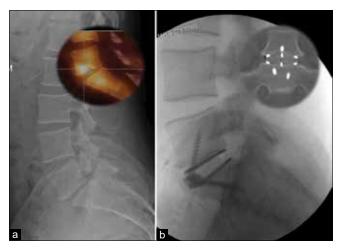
Stand alone Anterior Lumbar Interbody Fusion for Isthmic Spondylolisthesis. (a) Standing X-ray. Degenerative Disc Disease with low-grade spondylolisthesis and pars defect. *Insert*. Discovertebral uptake on bone scan. (b) 6-month postoperative X-ray and (*Insert*) computer tomography demonstrating restored disc height, evidence of early graft integration and no subsidence or lucency
